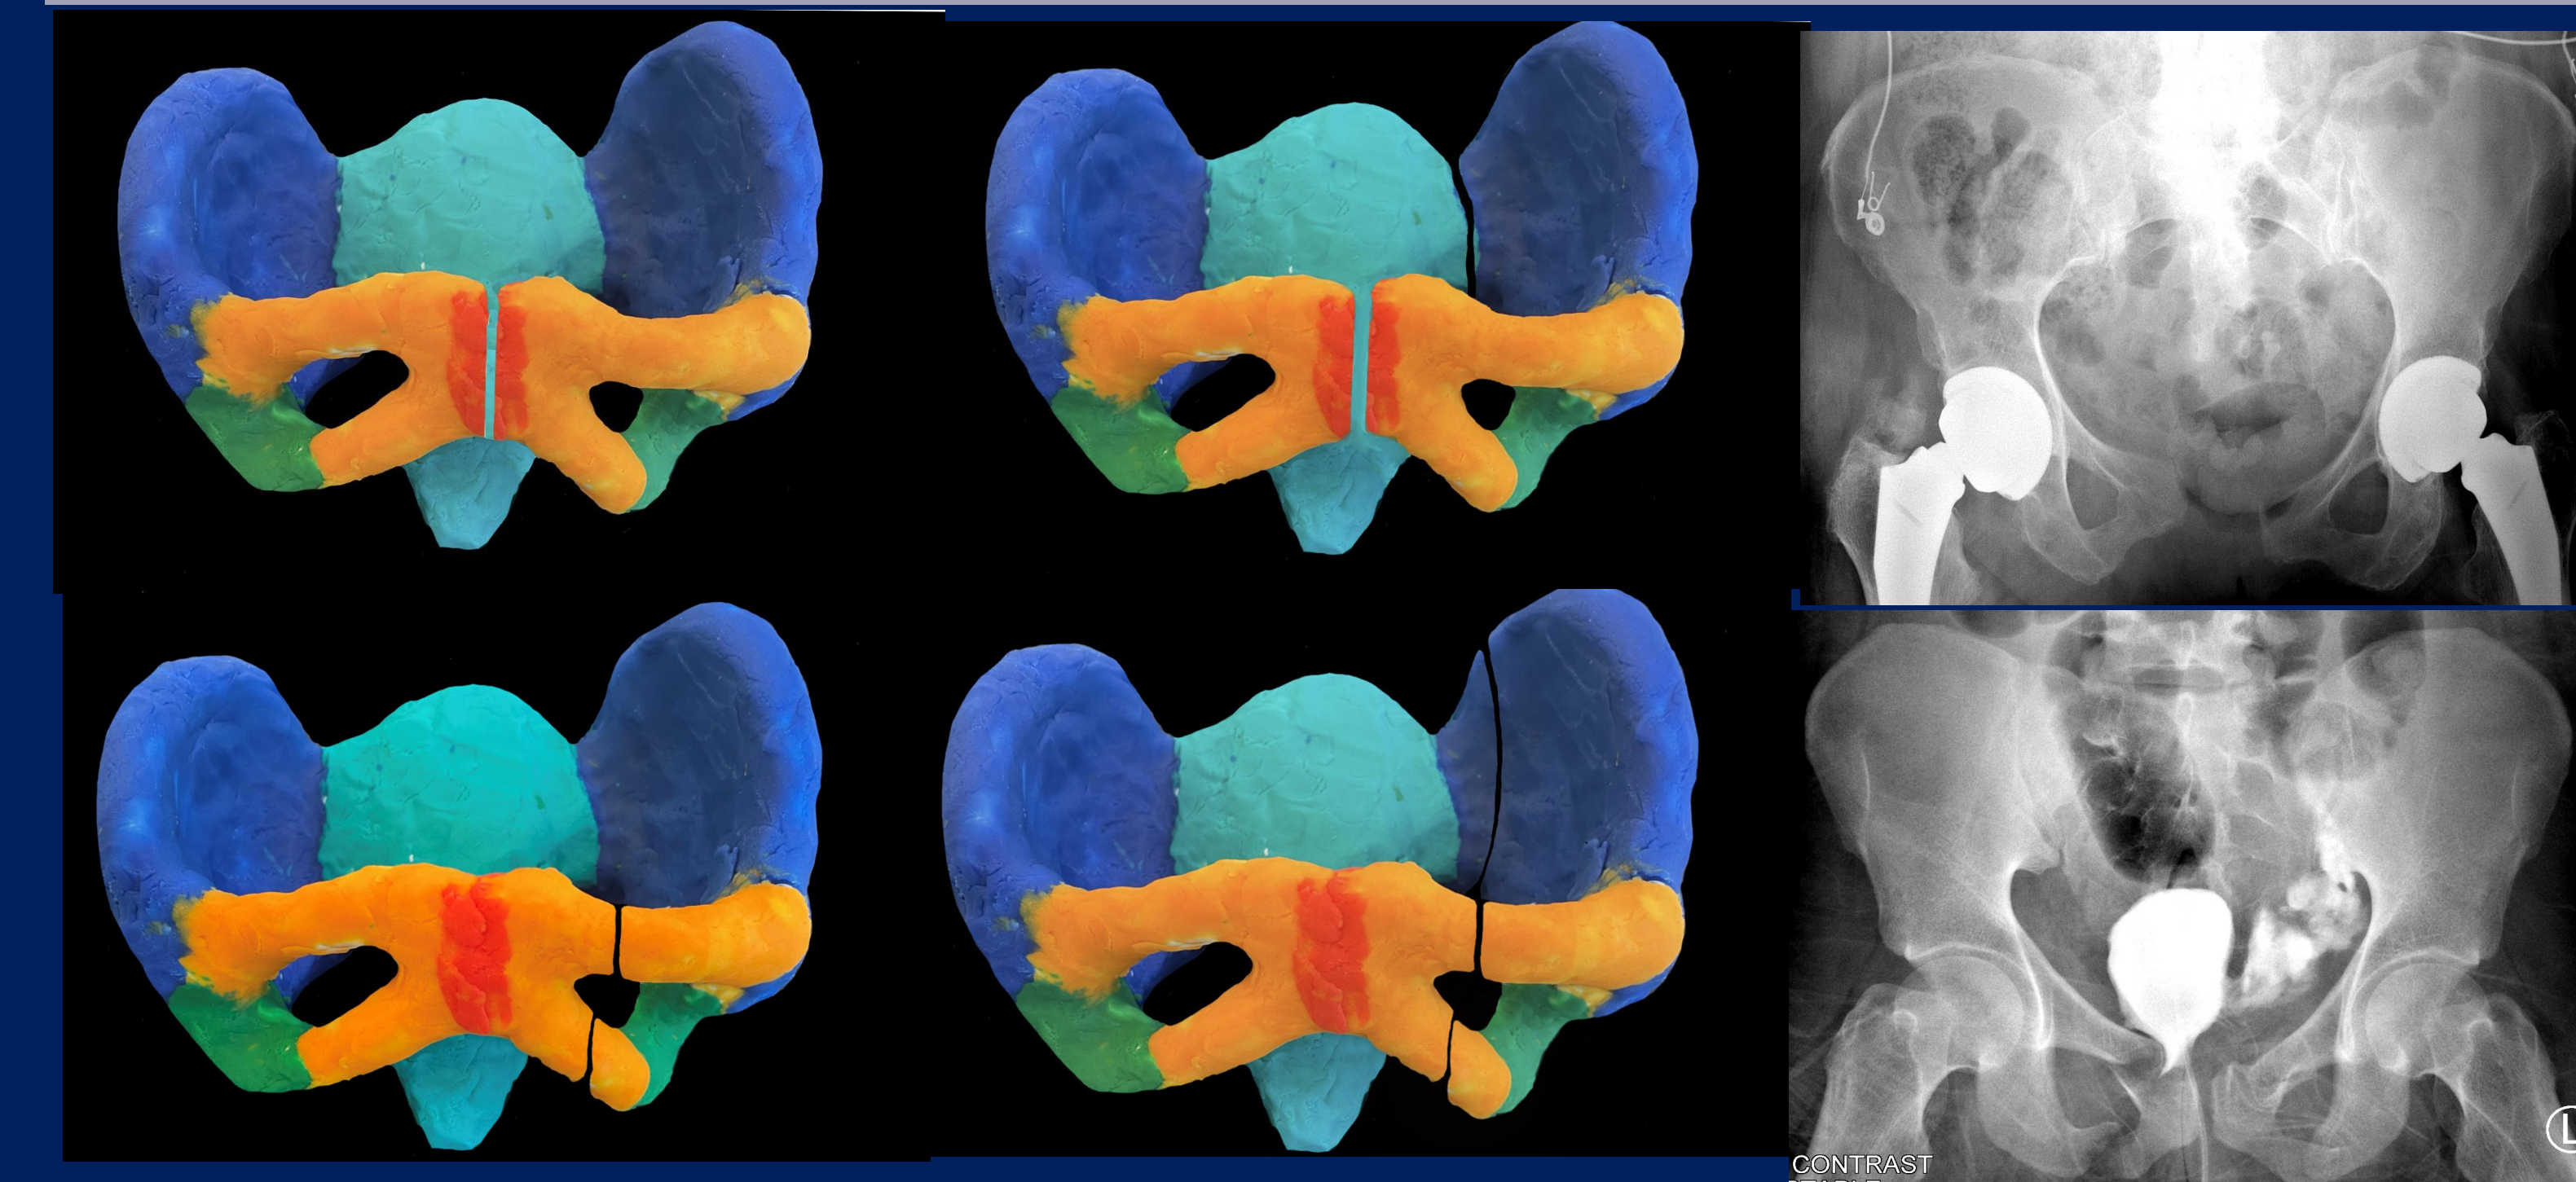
Clay models of the pelvis demonstrating anterior posterior compression injuries (top row) and lateral compression injuries (bottom row). Two frontal radiographs of the pelvis demonstrating AP compression injury (top right) and lateral compression injury (bottom right).
